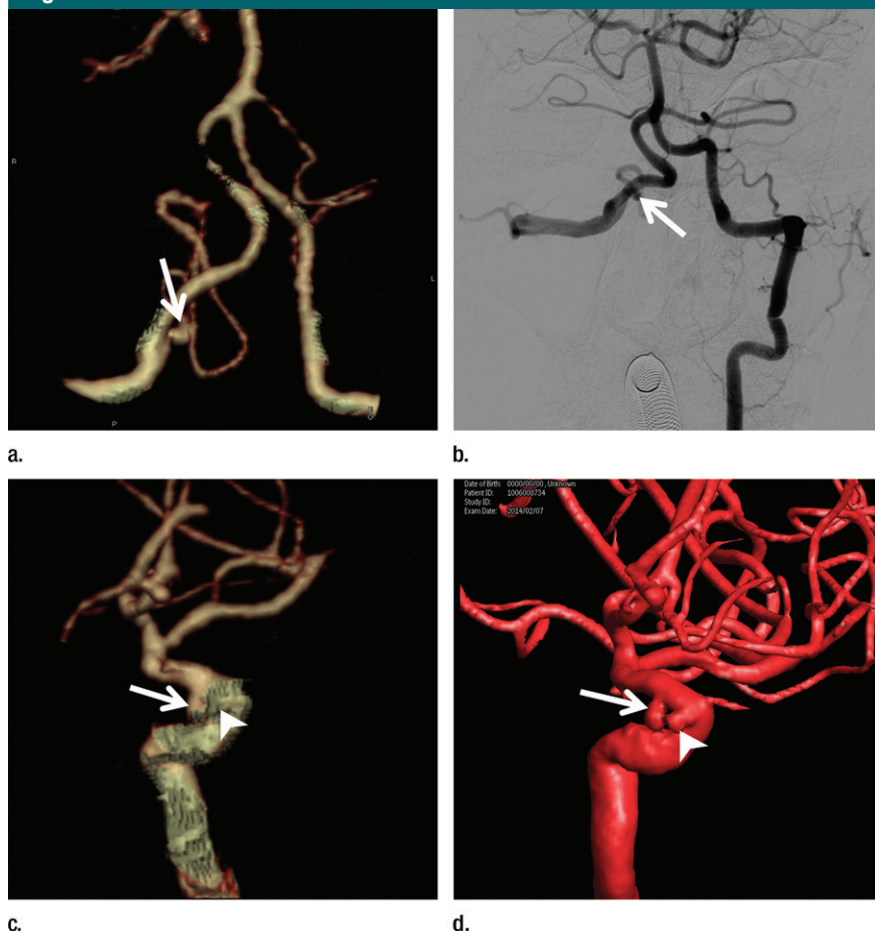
Two misdiagnosed aneurysms in two patients. (a) Volume-rendered CT angiography image shows reported aneurysm at right posterior inferior cerebellar artery (arrow) with maximal diameter of 3.8 mm measured at CT angiography in a 43-year-old man, and (b) conventional DSA image does not show the aneurysm (arrow) in that patient. (c) Volume-rendered CT angiography image shows one aneurysm at the left ophthalmic artery segment of internal carotid artery (arrow) in a 64-year-old man, whereas (d) volume-rendered 3D DSA image clearly shows two adjacent aneurysms in this location: one is 3.4 mm (arrow) and the other is 2.5 mm (arrowhead) in diameter, respectively. CT angiography missed the smaller aneurysm (arrowhead in c) because of overshooting bone removal.
